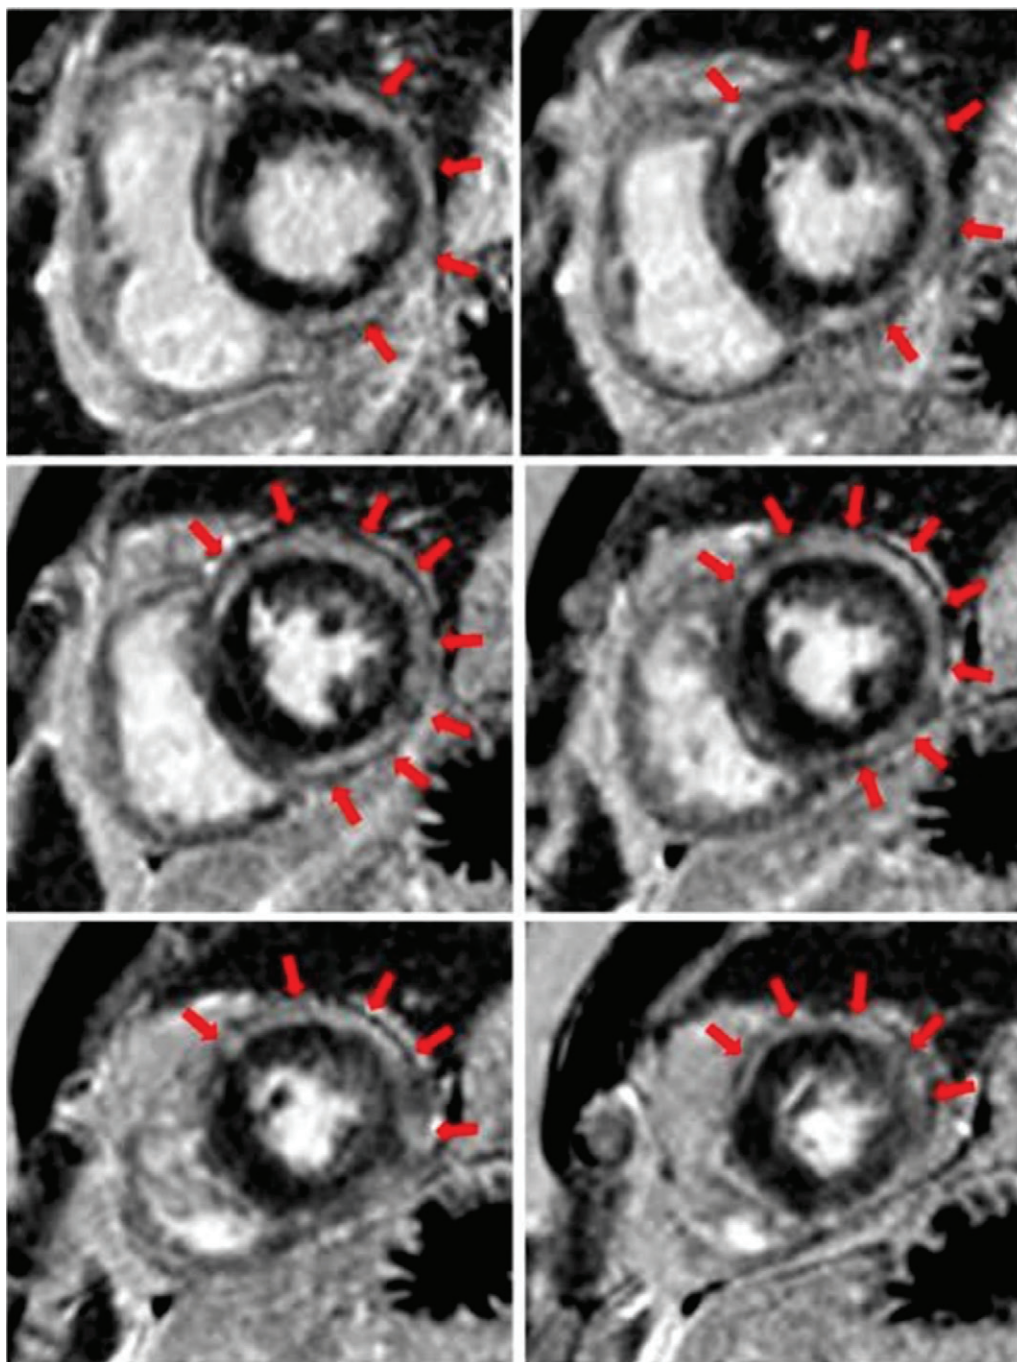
Ringlike late gadolinium enhancement (LGE). In a retrospective observational study from an ongoing international ventricular arrhythmia cardiac MRI registry, the presence of a specific midmyocardial and/or subepicardial ringlike LGE pattern was associated with a particularly high risk of malignant arrhythmic events, which was independent of the total LGE burden and presence of other additional risk factors. Cardiac MRI scans were obtained in a 54-year-old man who presented with palpitations related to multifocal premature ventricular contractions. Images show a “ringlike” pattern of subepicardial myocardial fibrosis (arrows) involving the left ventricular free wall. (Adapted, with permission, from reference 23.)
